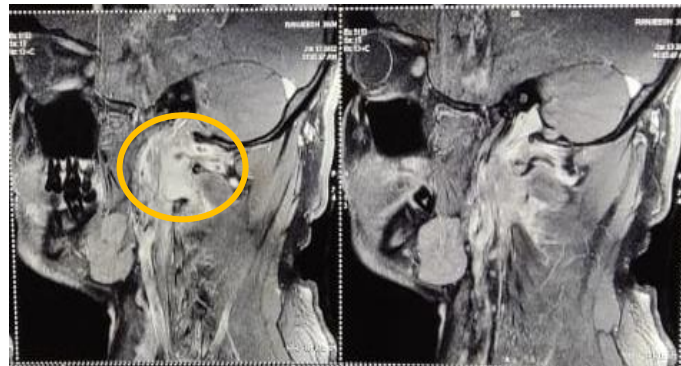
MRI Cervical spine showing T2 hyperintense lesion extending anteriorly in front of the anterior tubercle to the prevertebral space on left side behind the longus capitus muscle.
